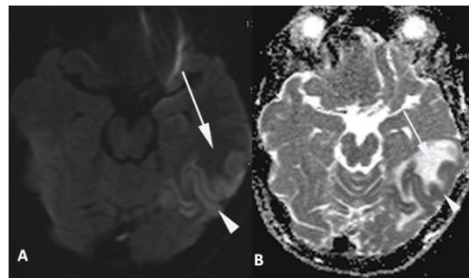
4. Five days after LMWH treatment, the improving of diffusion because of cytotoxic oedema in DWI images (A-B) (arrowheads) and the appearance of increased diffusion areas secondary to vasogenic oedema (arrow).
